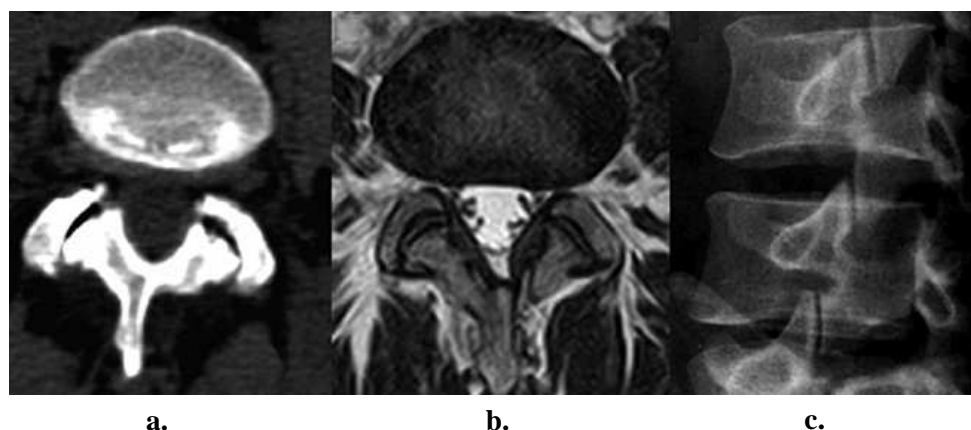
Examples of images of the facet joints a. CT scan b. MRI c. Oblique radiograph. Adapted from Kalichman and Hunter (2007).
